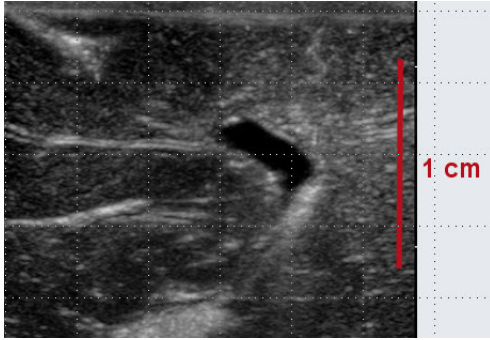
Images of detailed anatomical structuring are possible and definitely improve the highly appreciated resolution in cerebral surgery demonstrating the amygdala/hippocampus in near field ultrasound through the resection cavity as shown in Fig. 10 B.
